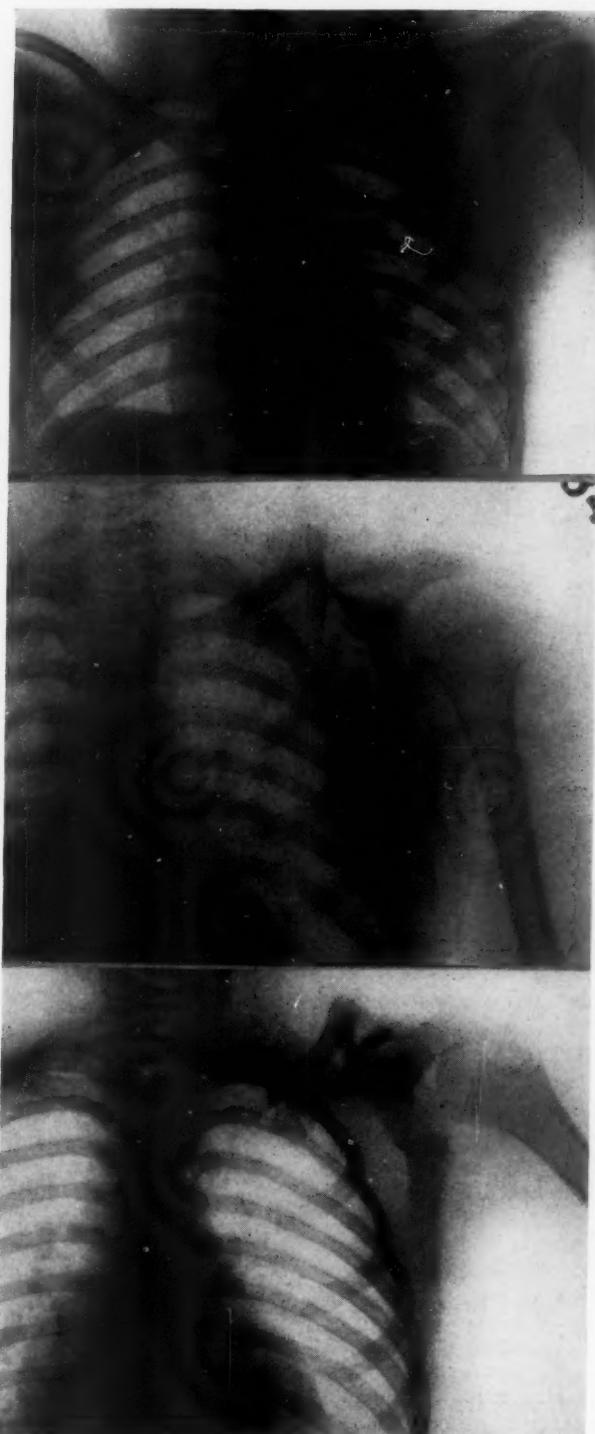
Roentgenogram showing the condition eight weeks after the accident. Note the formation of new bone between the inner fragment and the acromion process.
